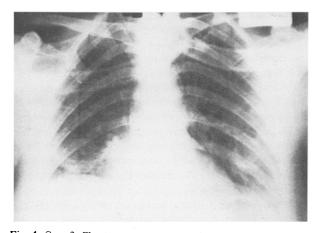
Case 2. Chest x-ray appearance of the same patient 14 days following pulmonary aspiration. The patient had been breathing spontaneously without C.P.A.P. for 3 days
